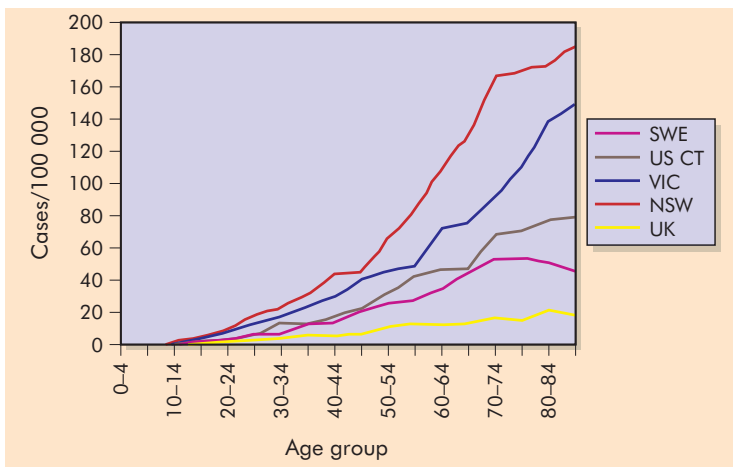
The melanoma incidence at different latitudes for men, in the UK, New South Wales Australia (NSW), Victoria Australia, Connecticut USA (US CT) and Sweden.
